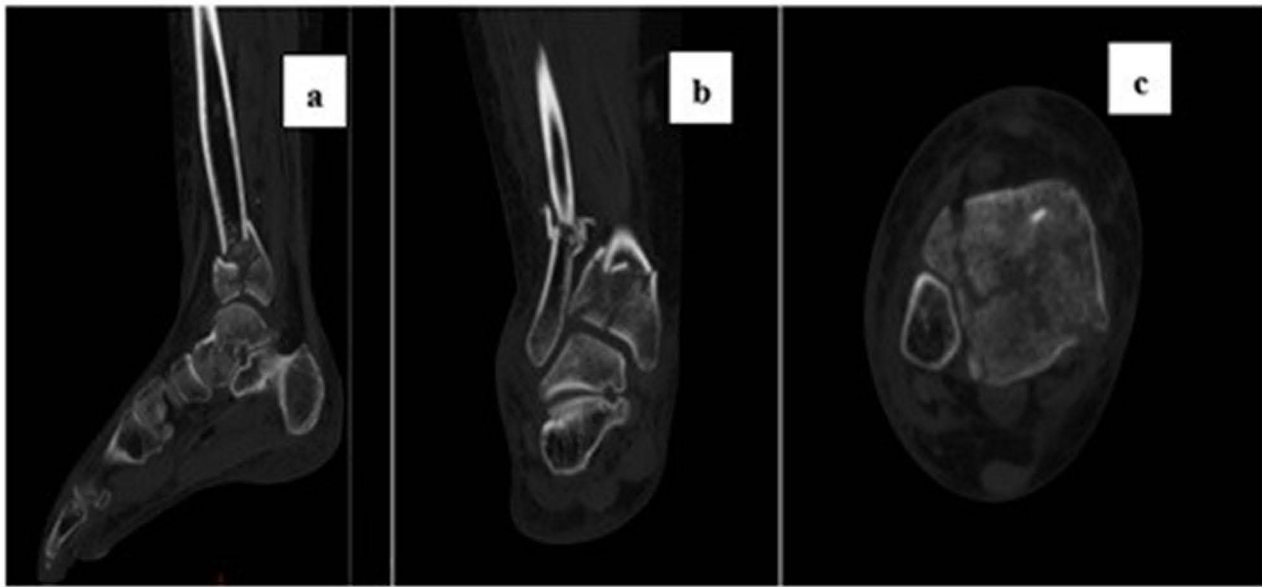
Preoperative Computed Tomography (CT) imaging data. (a) The sagittal view of the CT scan shows a fracture of the distal tibial articular surface. (b) The coronal view of the CT scan reveals a fracture of the distal tibial articular surface and a fracture of the fibular shaft. (c) The transverse section of the CT scan indicates a comminuted fracture of the distal tibial articular surface.
